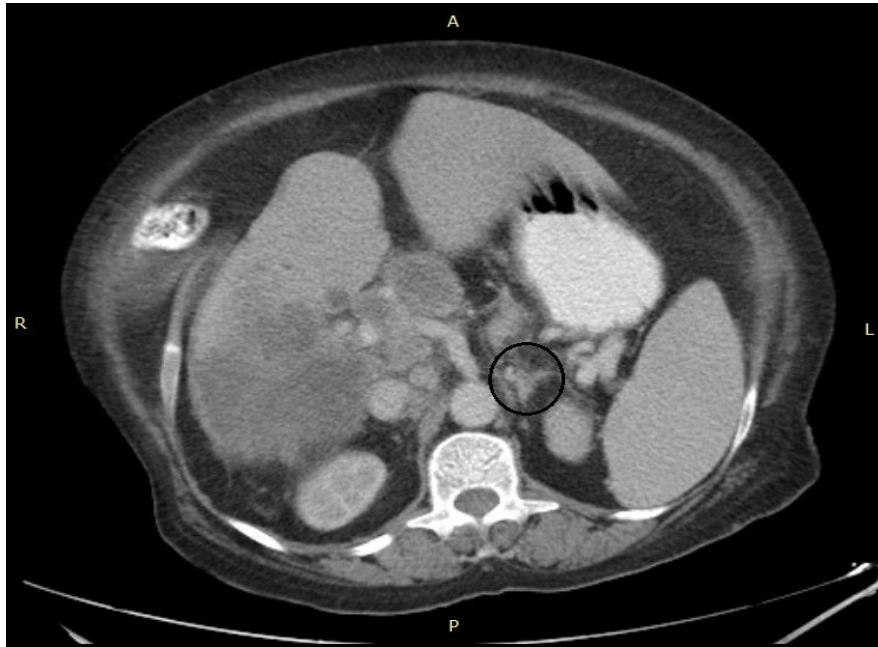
Axial CT image for Male (42 years) shows left adrenal gland (Y shape).
